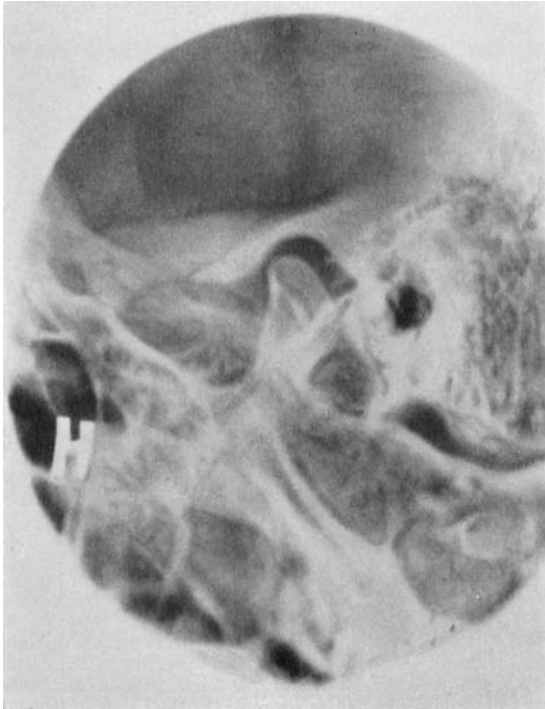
X-ray of the right mandibular joint from the same case as no. 9, October 1, 1949.
